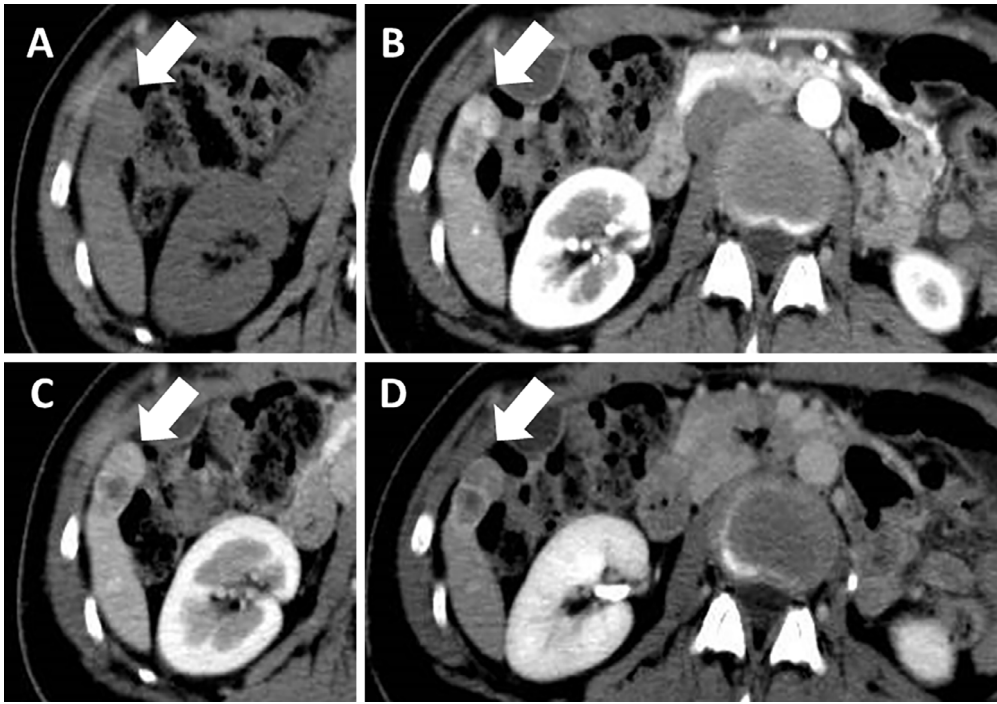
Dynamic computed tomography at the time of admission showed an enlarged tumor (17×34 mm; arrows) (A). The lesion was heterogeneously enhanced during the arterial phase (B) and washed out during the portal vein phase (C). It also presented as a hypointense lesion at the equilibrium phase (D).
